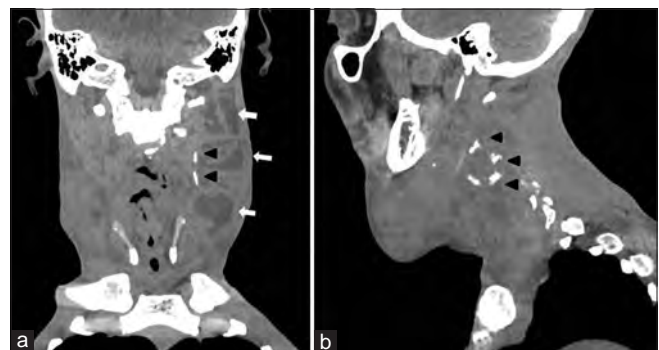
(a) coronal and (b) sagittal computed tomography scan of the neck showing multiple discrete oval masses of varying sizes in the lateral aspect of the neck and submandibular regions bilaterally with some having hypodense area of fluid density (arrows) and others show peripheral curvilinear calcifications (arrow heads) –representing lymphadenopathy
